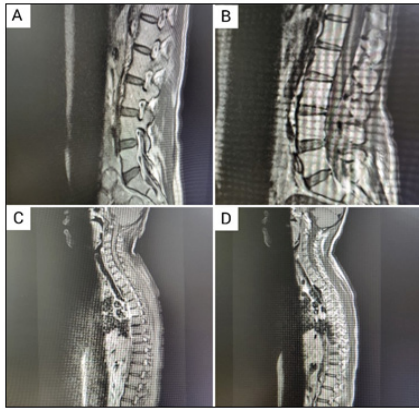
Sagittal T2-weighted MRI of the lumbosacral spine (A, B) and Sagittal Post-Contrast T1-weighted Magnetic resonance imaging (MRI) of the Whole Spine (C, D) showing patchy meningeal thickening from D1-L3
